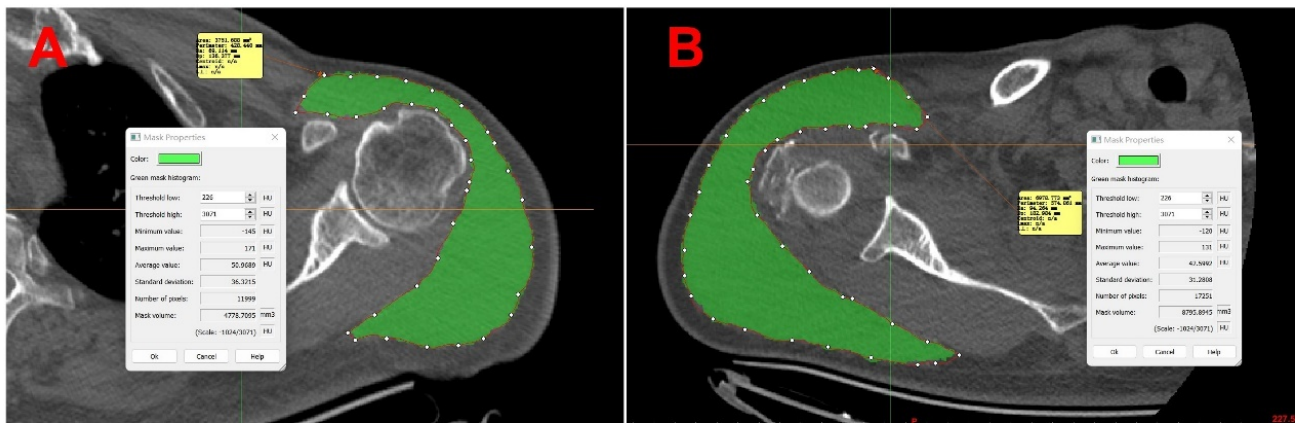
Measurement of cross-sectional area and mean computed tomography values of the deltoid muscle at the top of the coracoid process.
